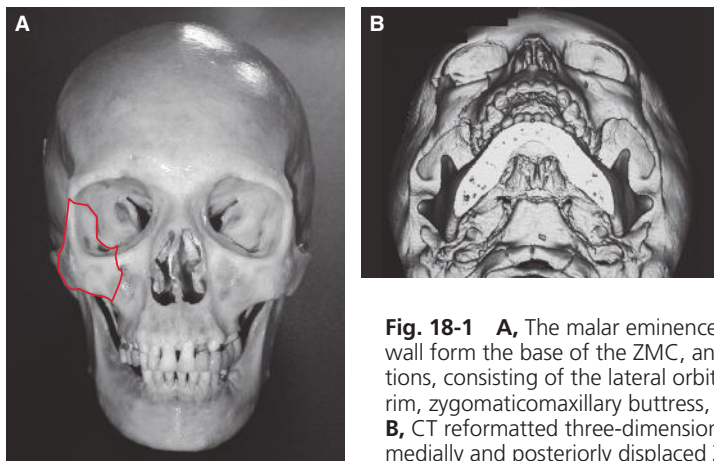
A, The malar eminence and lateral orbital wall form the base of the ZMC, and it has four projections, consisting of the lateral orbital rim, inferior orbital rim, zygomaticomaxillary buttress, and zygomatic arch. B, CT reformatted three-dimensional image showing a medially and posteriorly displaced ZMC fracture.
